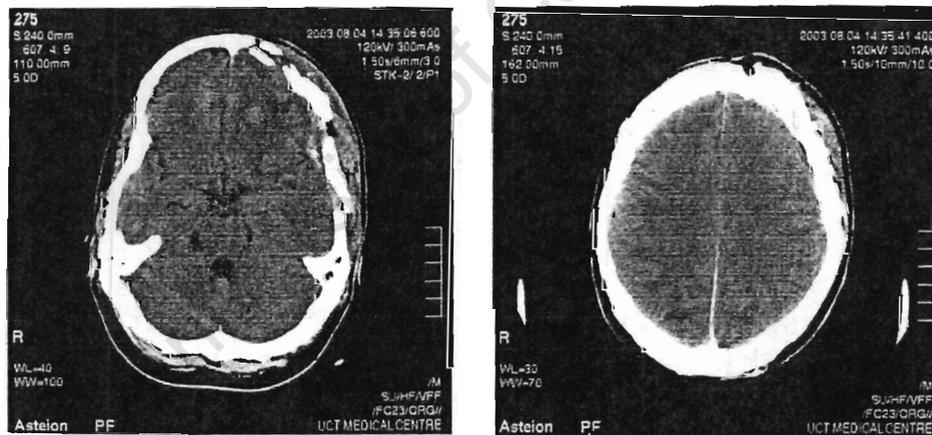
Post-operative CT head scans of patient JZ
